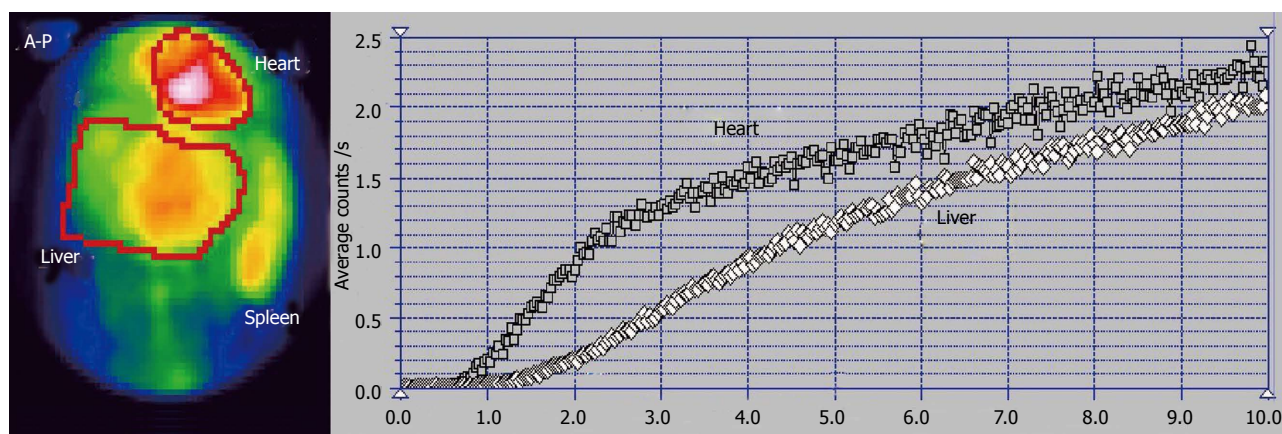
Per-rectal portal scintigraphy of a patient with Budd-Chiari syndrome with old obstruction of the middle and right hepatic veins and recent obstruction of the left hepatic vein.
